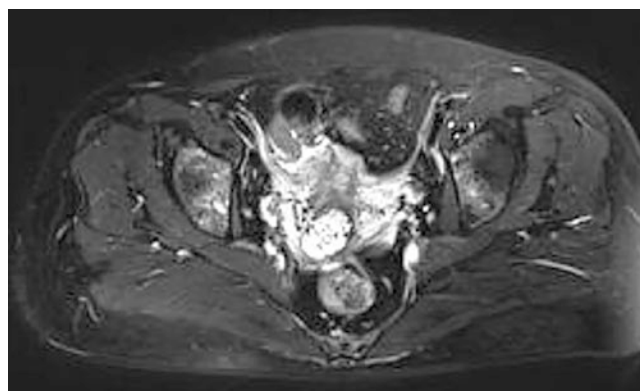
Axial T2-weighted image. This image demonstrated enlarged, well-defined, high-signal intensity multilocular cystic lesions within the stroma of the cervix. A large number of small cysts were partially surrounded by many larger cysts that resemble the “cosmos pattern” described in LEGH
